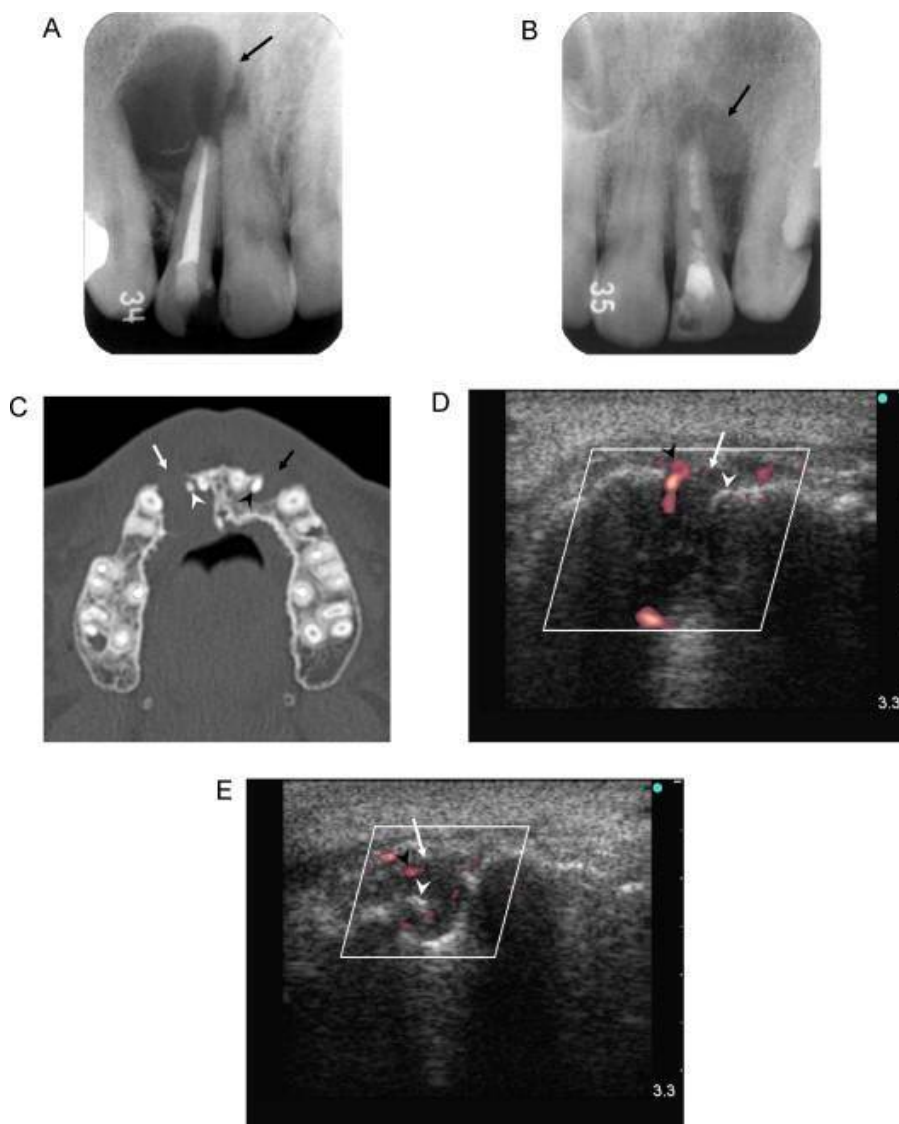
Ultrasound in Cyst Detection
